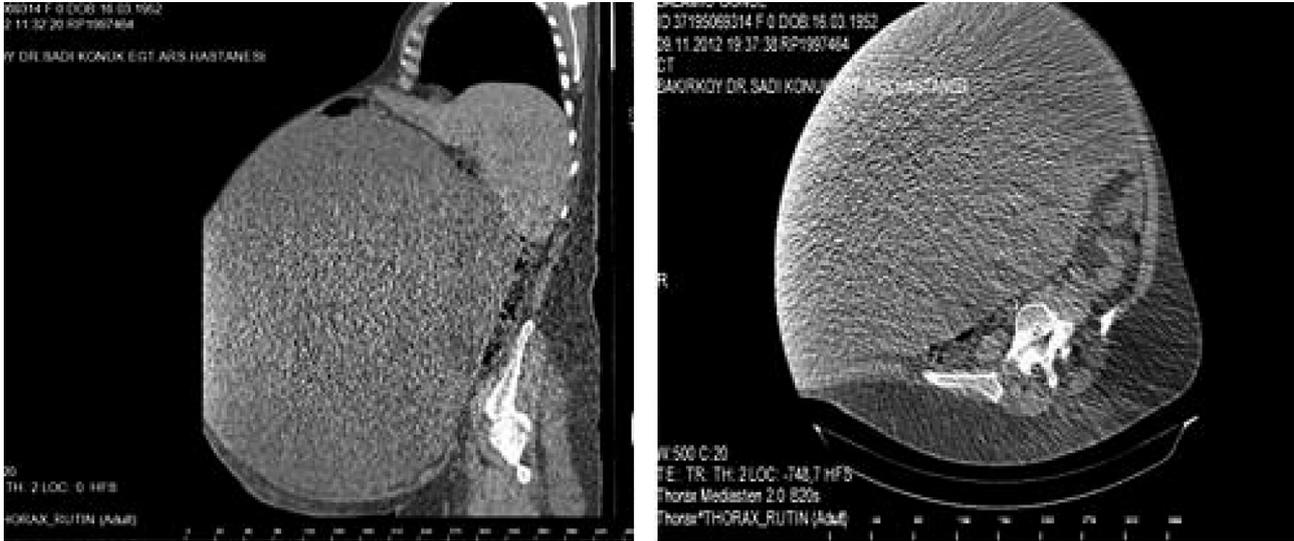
The abdominal computed tomography of the patient.
